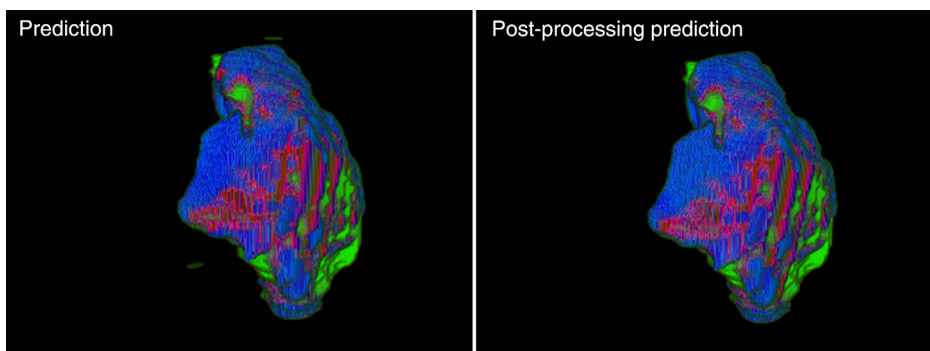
Reconstructed predicted infarct volumes from the CNN utilized in this study. Green regions indicate predicted infarct, blue indicates DWI infarct, and maroon indicates overlapping infarct. Note the removal of the small erroneously segmented infarct from the original image following postprocessing.
